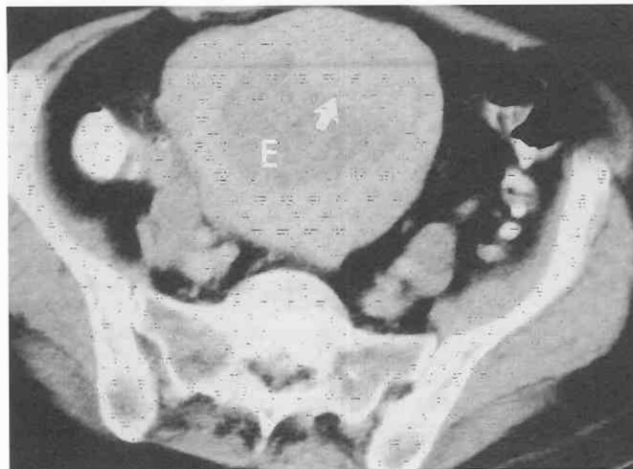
Endometrial cancer. CT scan through the uterus shows a distended endometrial cavity (E) containing enhancing tumor (arrow).
